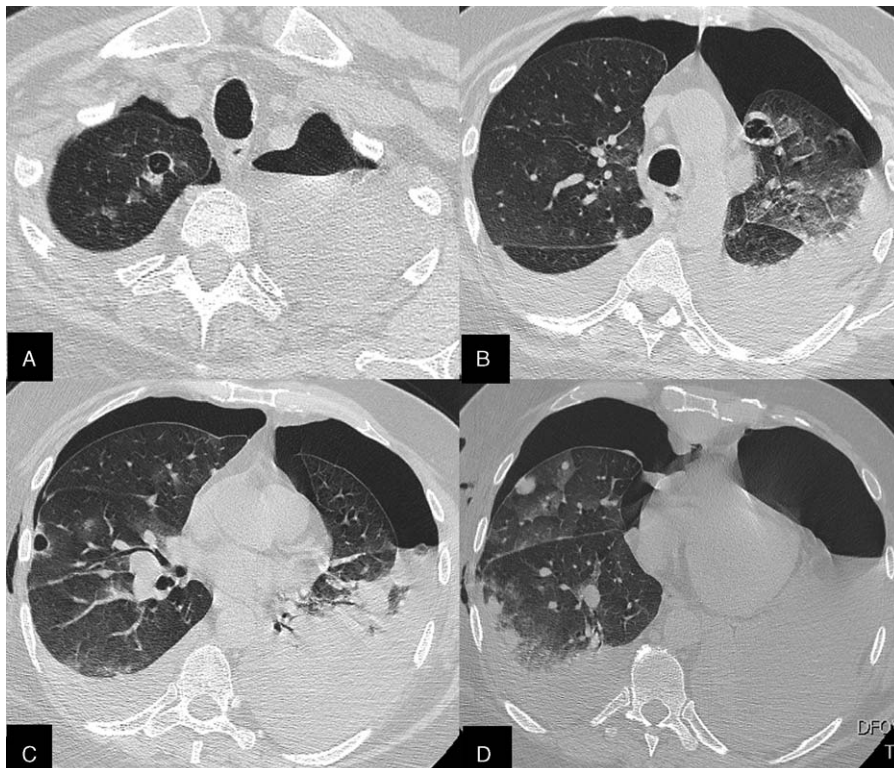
Patient 4. CT scan shows bilateral cysts, some of these with thick wall as in the anterior segment of left upper lobe. Some solid nodules are also present, particularly in right middle and lower lobe. Both the cystic lesions and nodules are suspicious of metastatic lesions. Bilateral hydropneumothorax is present.
